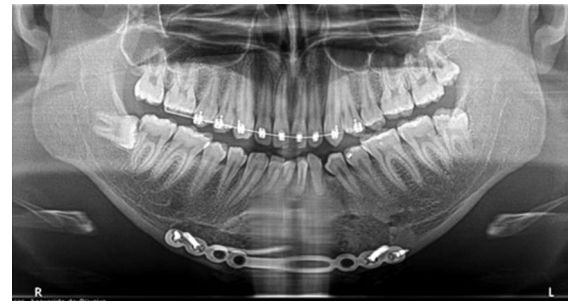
Post-surgical radiographic aspects (40 days): absence of complications.
